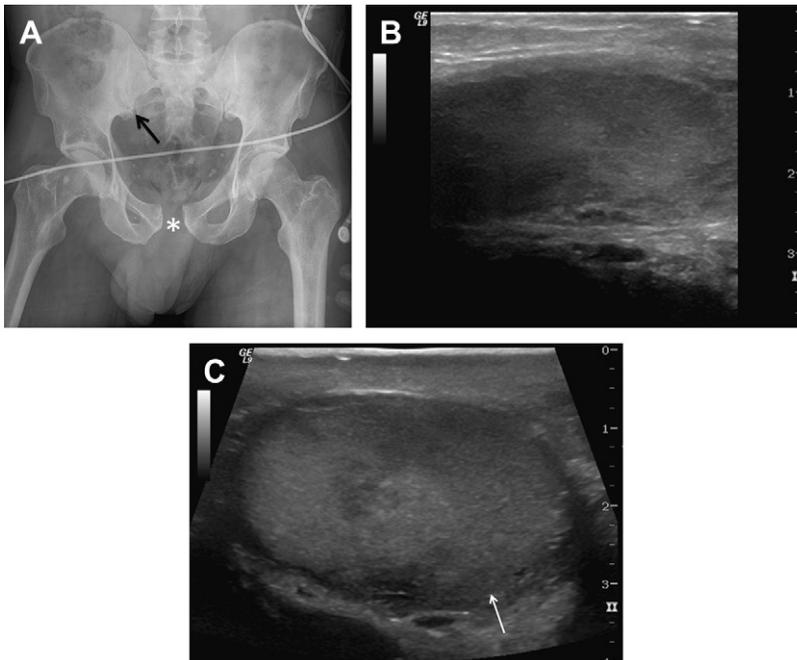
Pelvic disruption with bilateral testicular injury. (A) Anteroposterior radiograph demonstrates an “open book” pelvic injury with diastasis of the symphysis pubis (asterisk) and widening of the right sacroiliac joint (arrow). (B) Sagittal image of the right testicle demonstrates heterogeneous echotexture filling the hemiscrotum without definable margins to indicate the tunica albuginea. Complete avulsion of the tunica albuginea was found at surgery with extrusion of the seminiferous tubules. The testicle was deemed nonviable and an orchiectomy was performed. (C) Sagittal image of the left testicle demonstrates heterogeneous echotexture consistent with intratesticular hematoma and poor tunica albuginea definition posteriorly (arrow). The testicular contour was grossly maintained. On surgical exploration, the left testicle was found to be “bruised with hematoma” but viable. Orchiopexy was performed.
